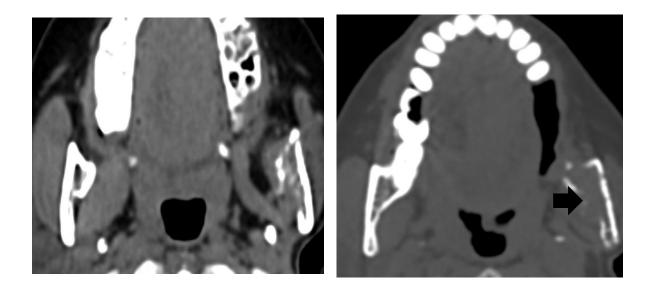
A: Axial CT image showing normal fat filled mandibular foramen on the right. B: Loss of fat and mandibular involvement denoting perineural spread on the left resulting in erosion (black arrow).
